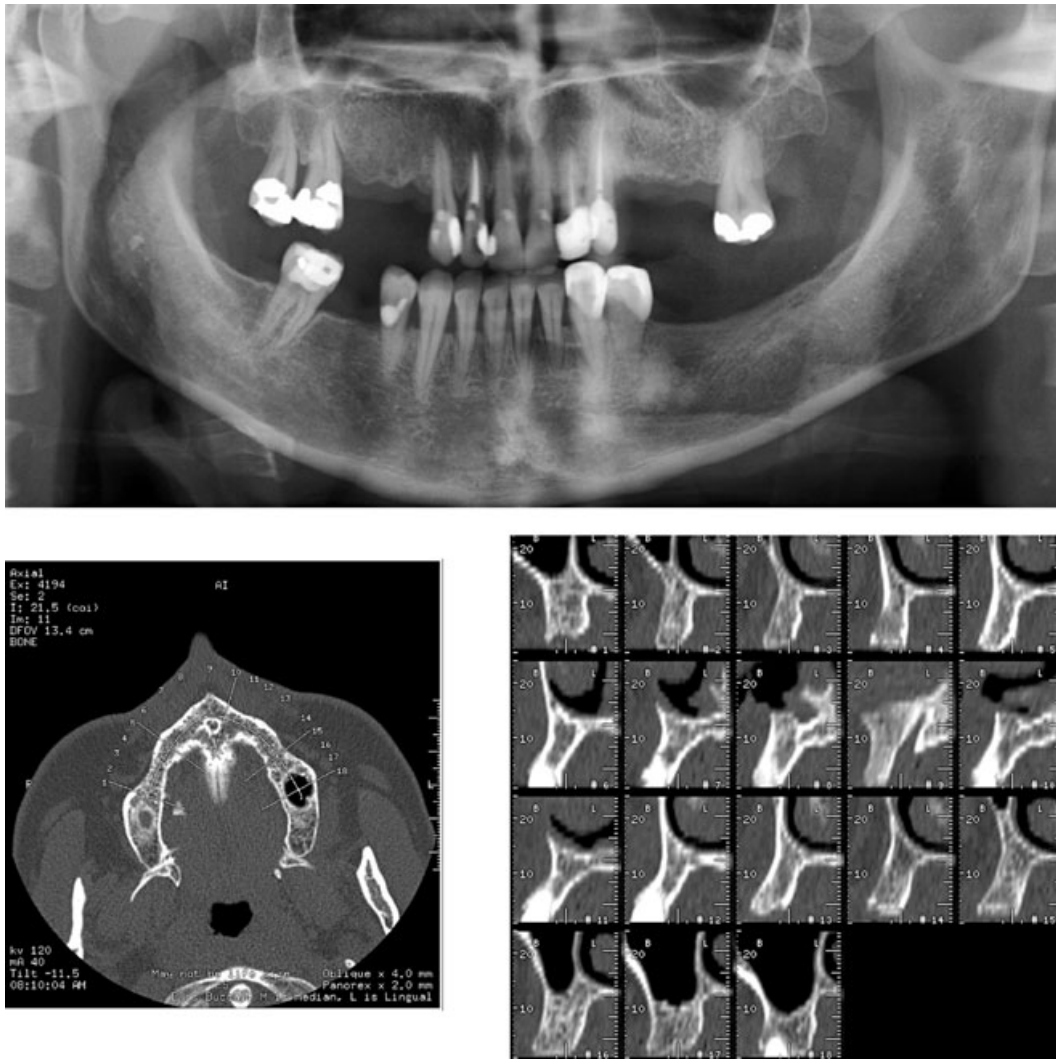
Computed tomography of the upper jaw where implants are planned to be installed on both sides. To the lower right are cross-sectional views from one side to the other, perpendicular to the curve seen in the axial view to the left.
